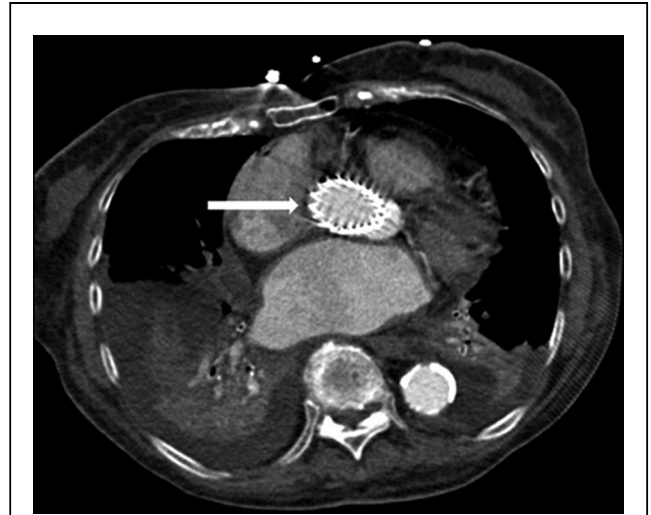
Computed Tomography of the Thorax With Contrast After Transcatheter Aortic Valve Implantation
